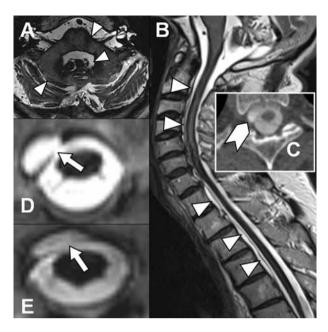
A. MRI of the posterior fossa, demonstrating the T2-hypointense rim around the surface of the brainstem, eighth cranial nerves and cerebellum; B. 3T spinal MRI, showing the anterior spinal epidural fluid collection (arrowheads) spreading from C2 to T12 (not shown); C. CT-myelography, with leaking of the contrast fluid from intradural space into the cavity; D, E. 3T spinal MRI: dural tears at the D6, D8-D9 levels, respectively.
